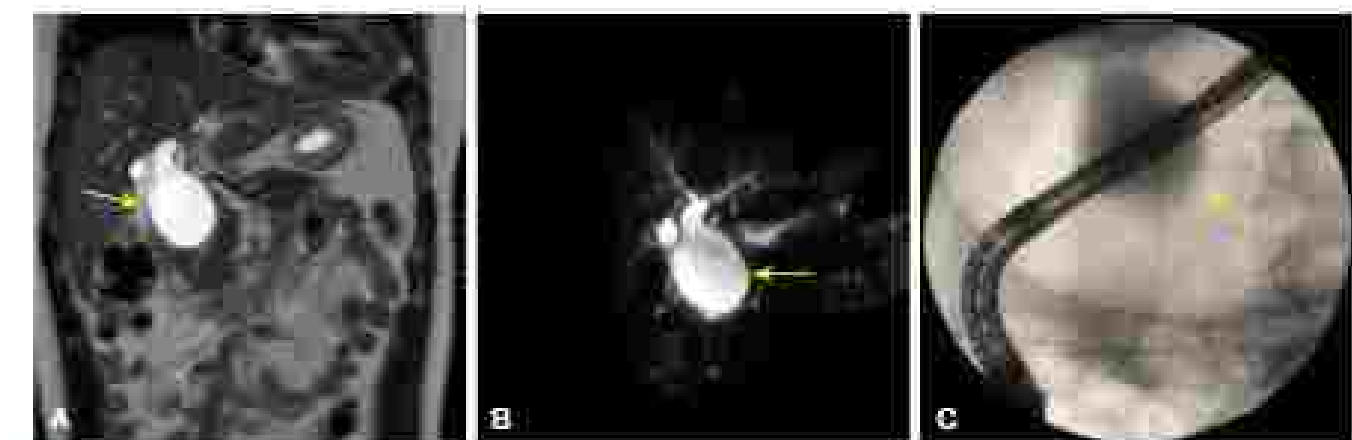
Magnetic resonance cholangiopancreatography and cholangiogram (cholangiopancreatography) of a type Ia choledochal cyst showing abnormal biliary dilation terminally distal to the hepatic duct junction. (A) Coronal magnetic resonance image. (B) Magnetic resonance image with three-dimensional reconstruction. (C) Cholangiogram.
